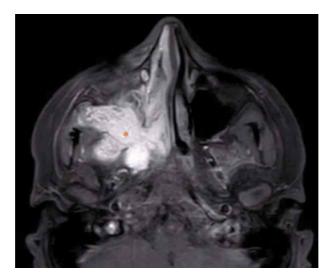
CE-MRI showing hyperintense tumor (*) in the infratemporal fossa.
